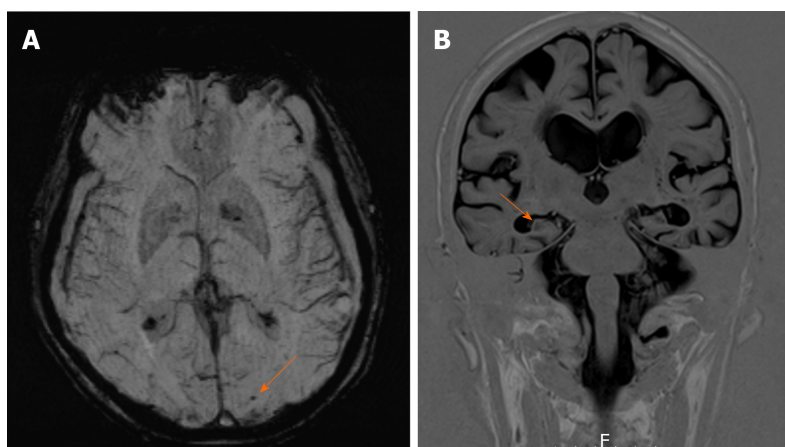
Magnetic resonance imaging of the patient. A: Susceptibility weighted magnetic resonance imaging (MRI) showing left occipital microhaemorrhage (arrow), suggestive of cerebral amyloid angiopathy; B: Coronal view T1-weighted MRI showing bilateral mesial temporal atrophy (arrow).
